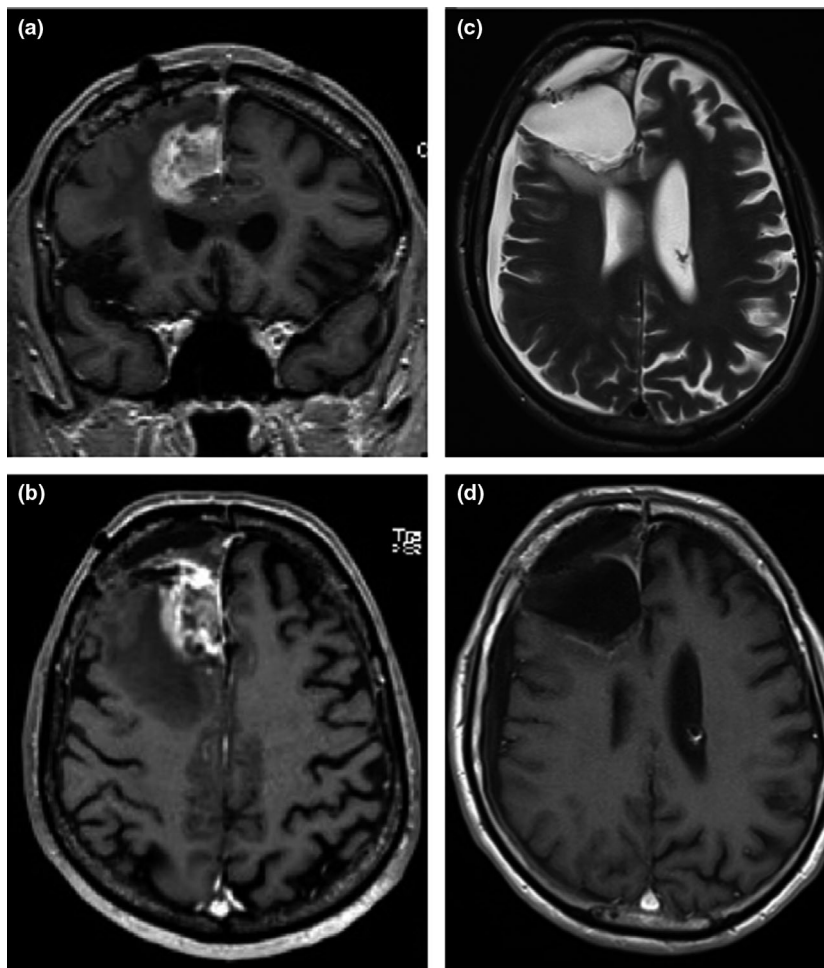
Coronal (a) and axial (b) T1 contrast-enhanced (CE) MRI showing right frontal glioma recurrence. First post-operative MRI showing slight ring of contrast enhancement (d) and T2 hyperintensity outside the surgical bed (c).
